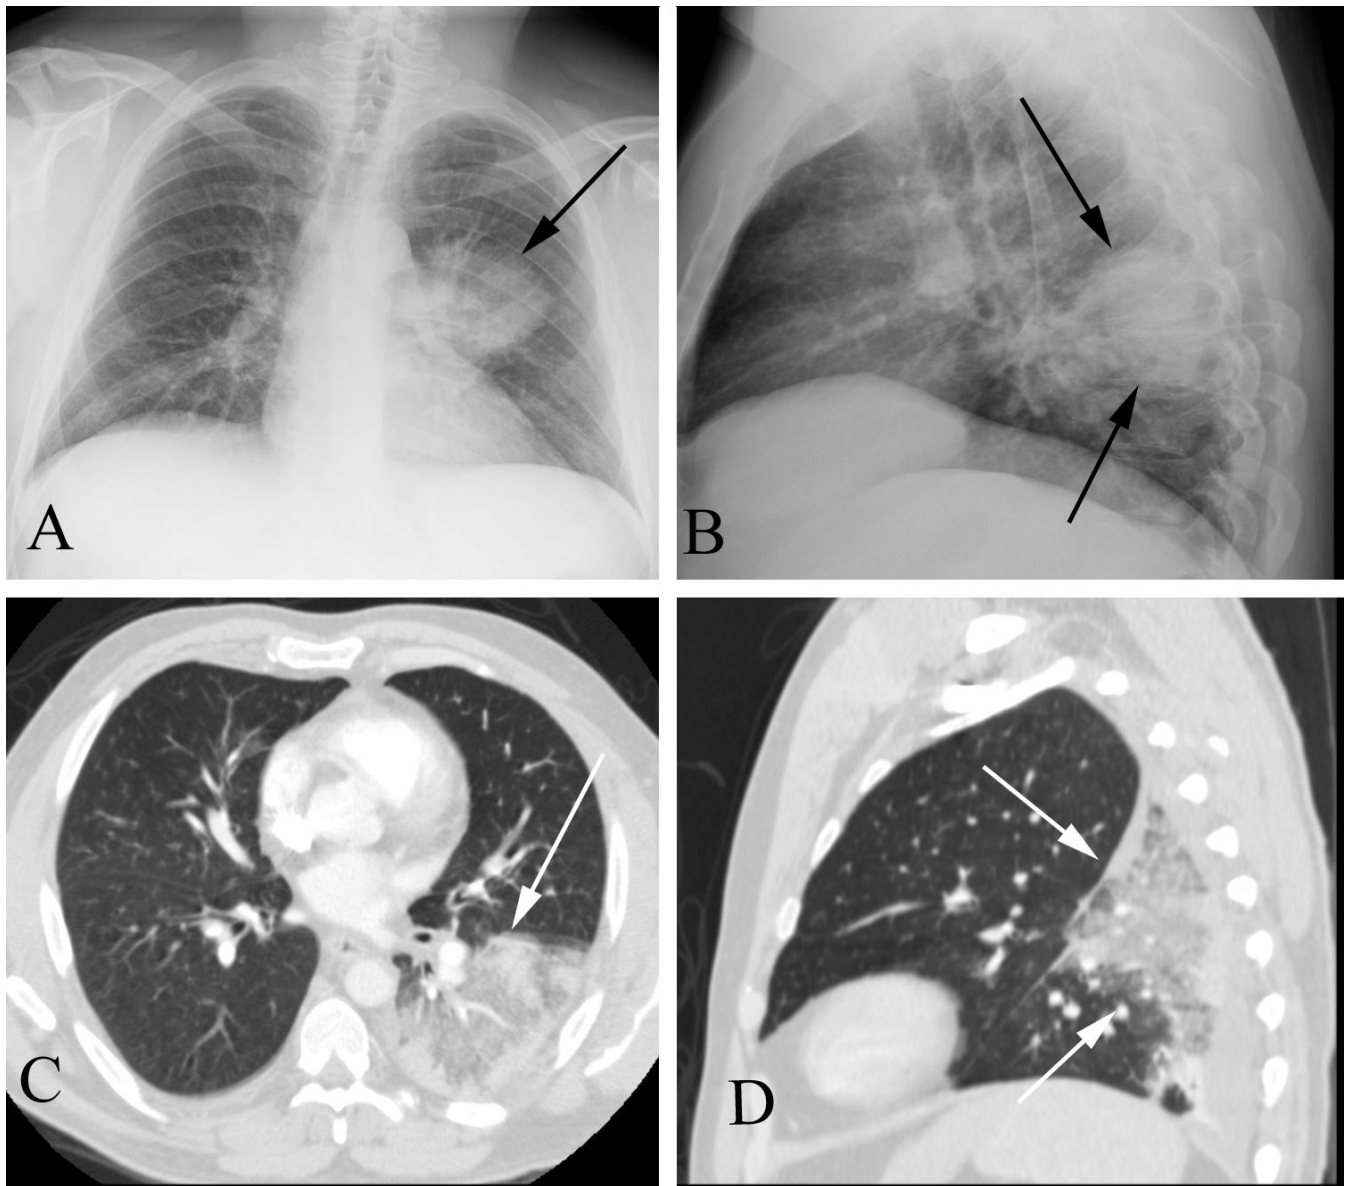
Pneumonia causing chest pain in a 47 year old man. A. PA CXR shows opacity in the mid left lung (arrow). B. Lateral CXR shows the opacity along the posterior chest wall (arrows). This is a so-called “round” pneumonia which mimics a mass. C. Axial CT shows consolidation in the left lower lobe (arrow). D. Sagittal reformatted CT shows consolidation along the posterior chest corresponding to the opacity seen on the plain film. Follow-up CXR (not shown) following treatment demonstrated clearing of the pneumonia.
